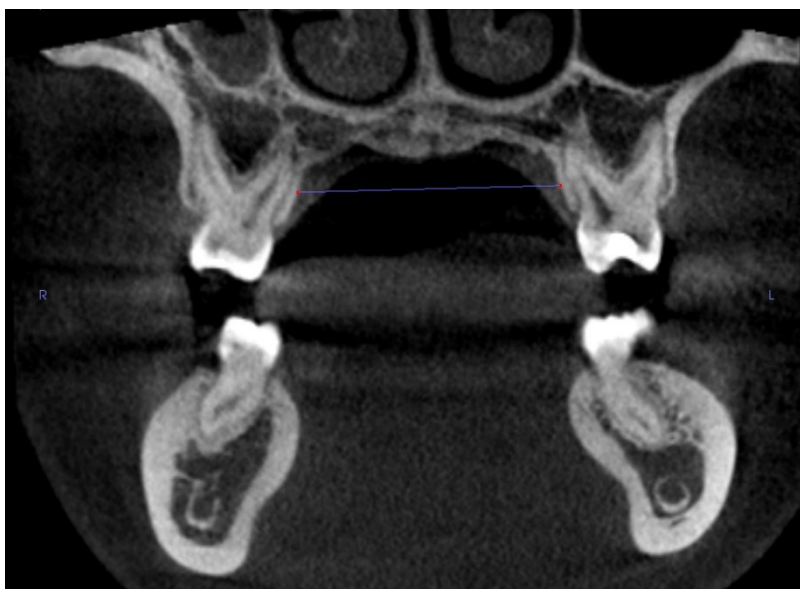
Measurement between lingual cemento-enamel junctions of maxillary first molars on a coronal CBCT image
